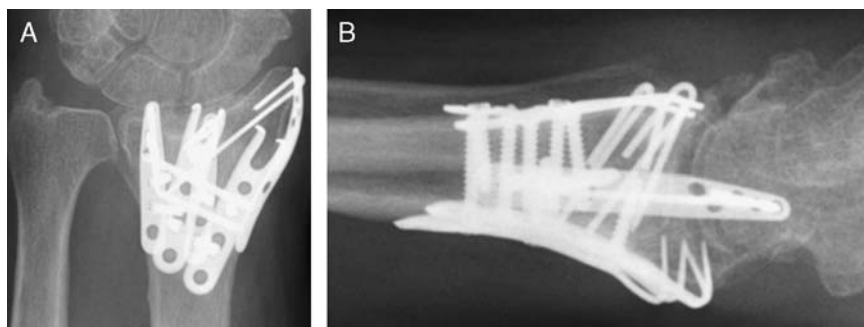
A, Postoperative posteroanterior x-ray after open reduction and internal fixation using 2 volar hook plates: one volar hook plate to capture and maintain reduction of the distal volar lunate facet/volar rim fragment and another volar hook plate to capture and maintain volar radial fragment. A radial column plate and 2 dorsal pin plate using fragment-specific fixation technique is also shown. B, Lateral x-ray demonstrating return of volar inclination and capture of the distal volar lunate facet/volar rim fragment.
